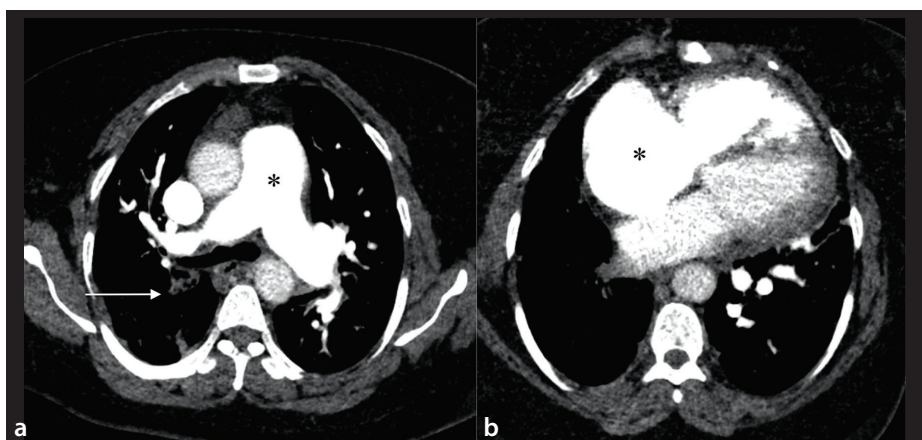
Axial computed tomography pulmonary angiography images. (a) Marked dilatation of the main pulmonary artery (star), exceeding the diameter of the adjacent ascending aorta due to pulmonary hypertension. Absence of visible vascular structures in the right lower lobe, suggestive of segmental occlusion due to chronic thromboembolic disease (white arrow). (b) Cardiomegaly with prominent right atrial and ventricular enlargement in pulmonary hypertension (star).
